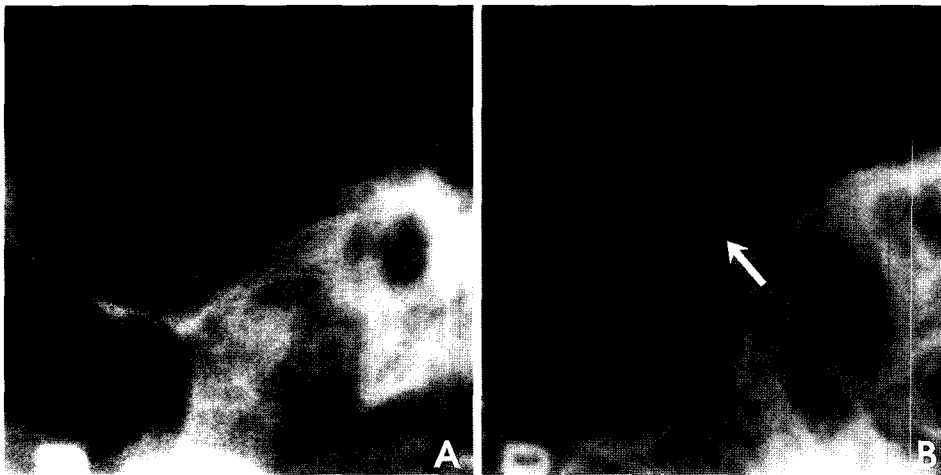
Transcranial radiographs show flattening on the articular eminence at affected side in the conservative treatment patient. A, immediately after treatment B, 21 months after treatment
